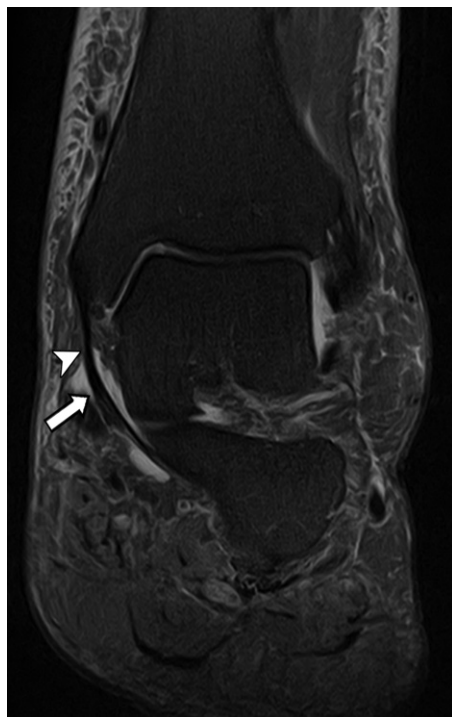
Normal tibiospring ligament in a 45-year-old woman with very mild AAFD. Coronal fat-suppressed proton-density-weighted MR image of the hindfoot shows a normal tibiospring ligament (arrowhead) fusing distally with the superomedial bundle of the spring ligament (arrow), making it the only portion of the deltoid without a distal bone attachment. It is often difficult to tell precisely where these two structures meet, because they form a continuous smooth band that hugs the medial talus bone. This band can be difficult to separate from the overlying PTT unless there is some regional fluid such as that present in this patient.
